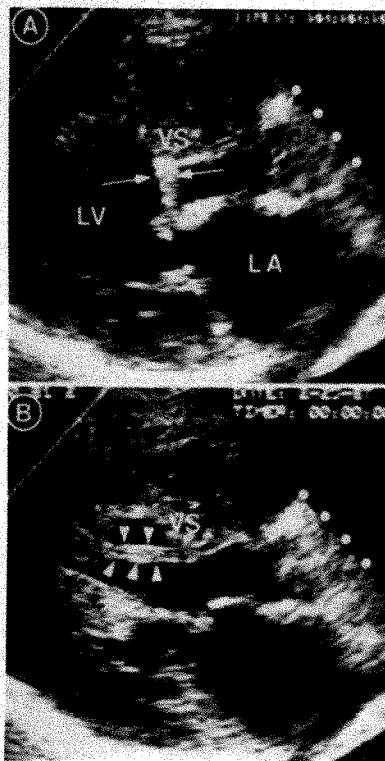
Two-dimensional echocardiograms obtained in the parasternal long-axis view. A, echo-dense anterior mitral leaflet with vegetation, showing systolic anterior motion and mitral-septal contact. Ventricular septum (VS) appears thickened. B, at end-diastole, in a slightly rotated cross-sectional plane that allows discrimination of the muscular band (arrows) from the true ventricular septum that appears to be of normal thickness. Calibration marks are 1 cm apart. LA = left atrium; LV = left ventricle.
